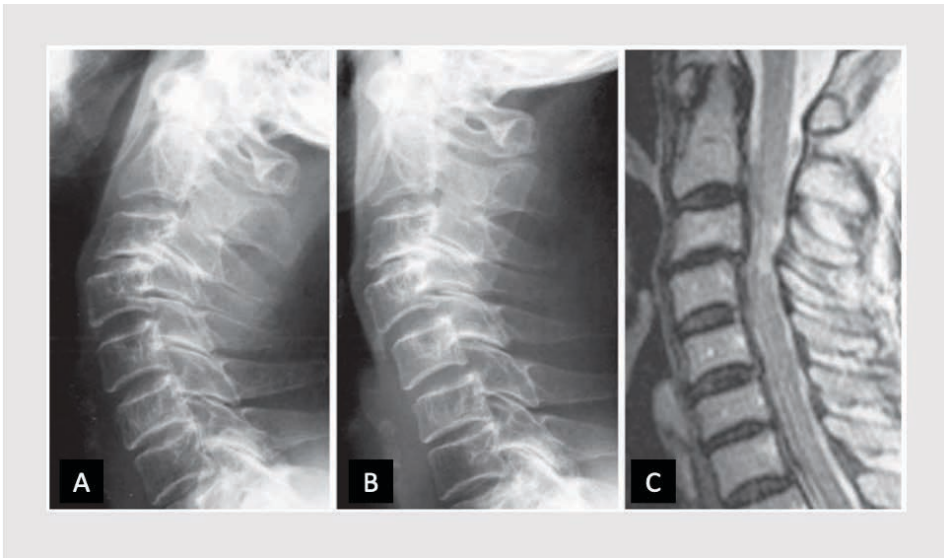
Spondylolisthesis: Retrolisthesis- Lateral view of the cervical spine with the neck in extension (A) and in neutral position (B). Sagittal T2-weighted MRI scan shows posterior degenerative spondylolisthesis, referred to as retrolisthesis, in a 76-year-old patient (C).¹⁸⁰
